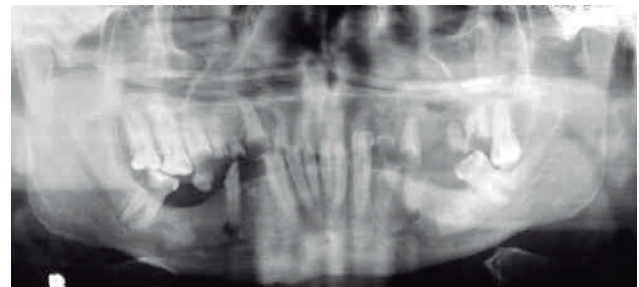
Panoramic radiograph showing the poor dental status.
